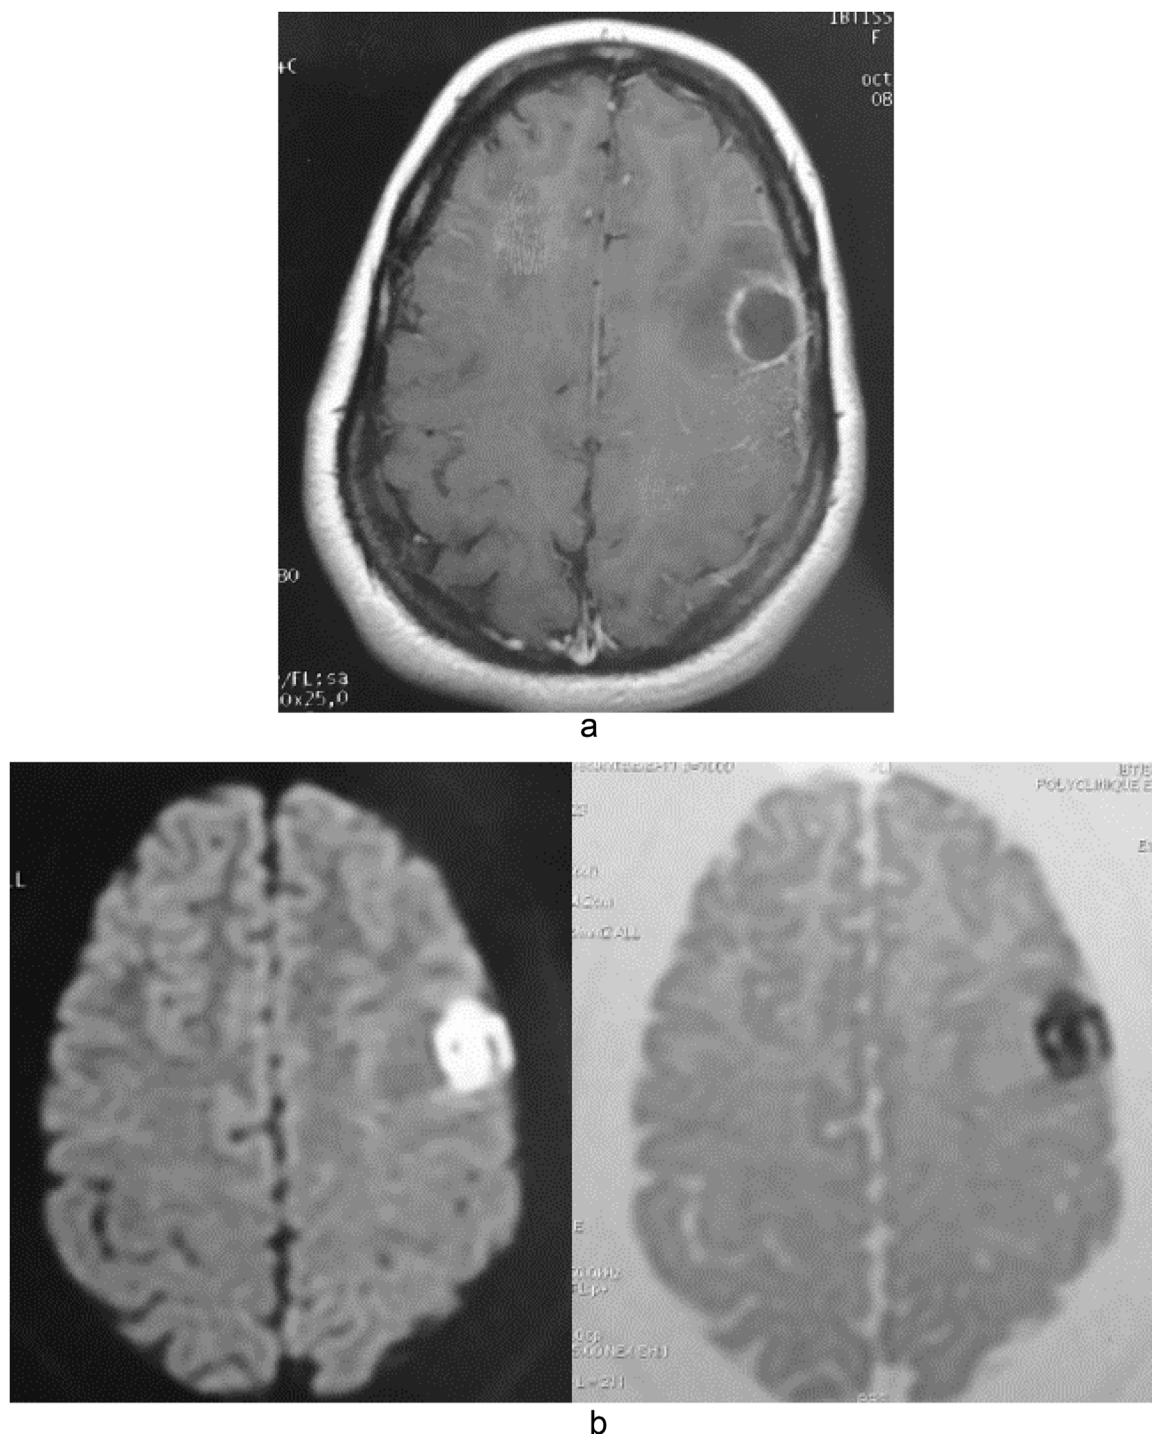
a: Brain MRI. Axial T1 weighted image with gadolinium injection showing a left frontal round well circumscribed lesion with peripheral enhancement. b: Trace DWI (left) showing a hyperintense lesion and a low ADC (right) indicating restricted diffusion.
